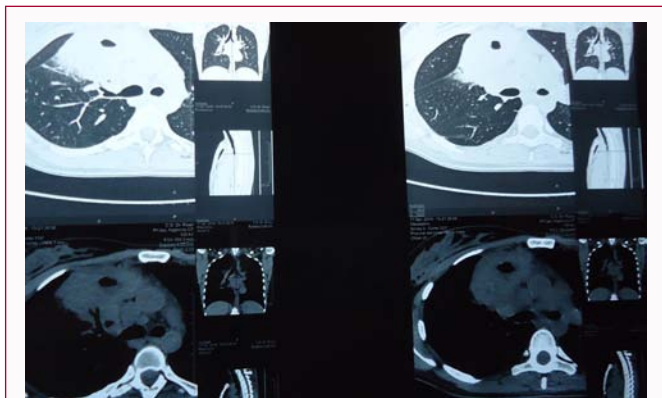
Initial CT scan shows a small cavity inside RUL lesion.
